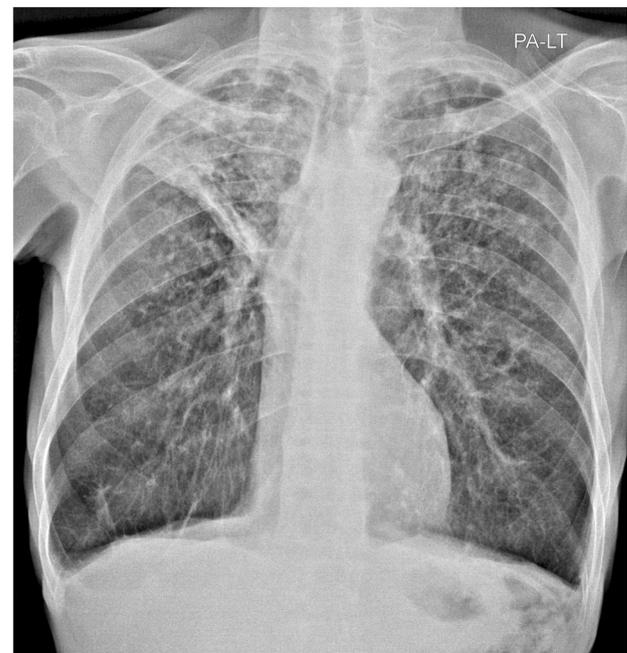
(A), (B) Chest X-rays of a 67 year-old ex-gold miner with 35 years of underground gold mining, obtained in January 2018 (on the right) and October 2019 (on the left).
